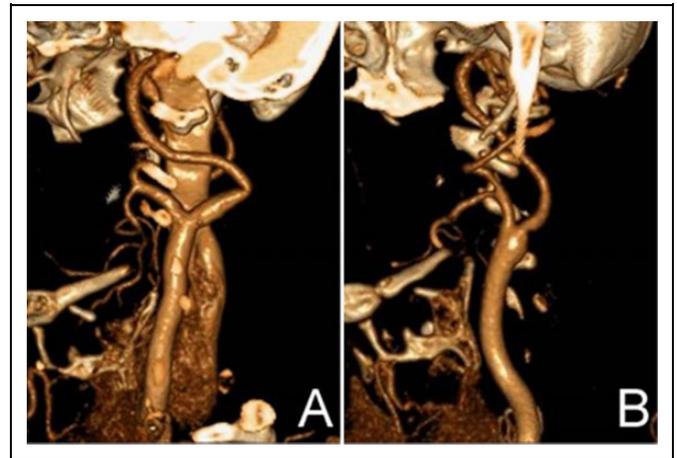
Computer tomography angiography (CTA) of the left carotid artery revealed kinking of the left internal carotid artery before operation, the angulation was greater than 60° (A, preoperative CTA), and the kinking disappeared after revascularization (B, postoperative CTA).
